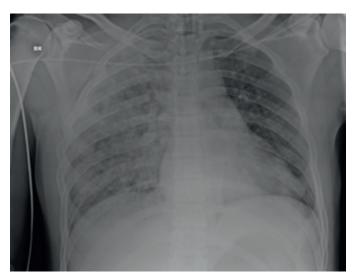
Chest X-Ray of a 29-Year-Old Man, Victim of a Motorbike Accident. The chest x-ray was obtained at arrival in the emergency department. Extensive right lung contusion ("white" lung), pneumothorax, multiple multifocal rib fractures, and a right flail chest can be seen. (Image courtesy Dr. Giovanni Babini.)
